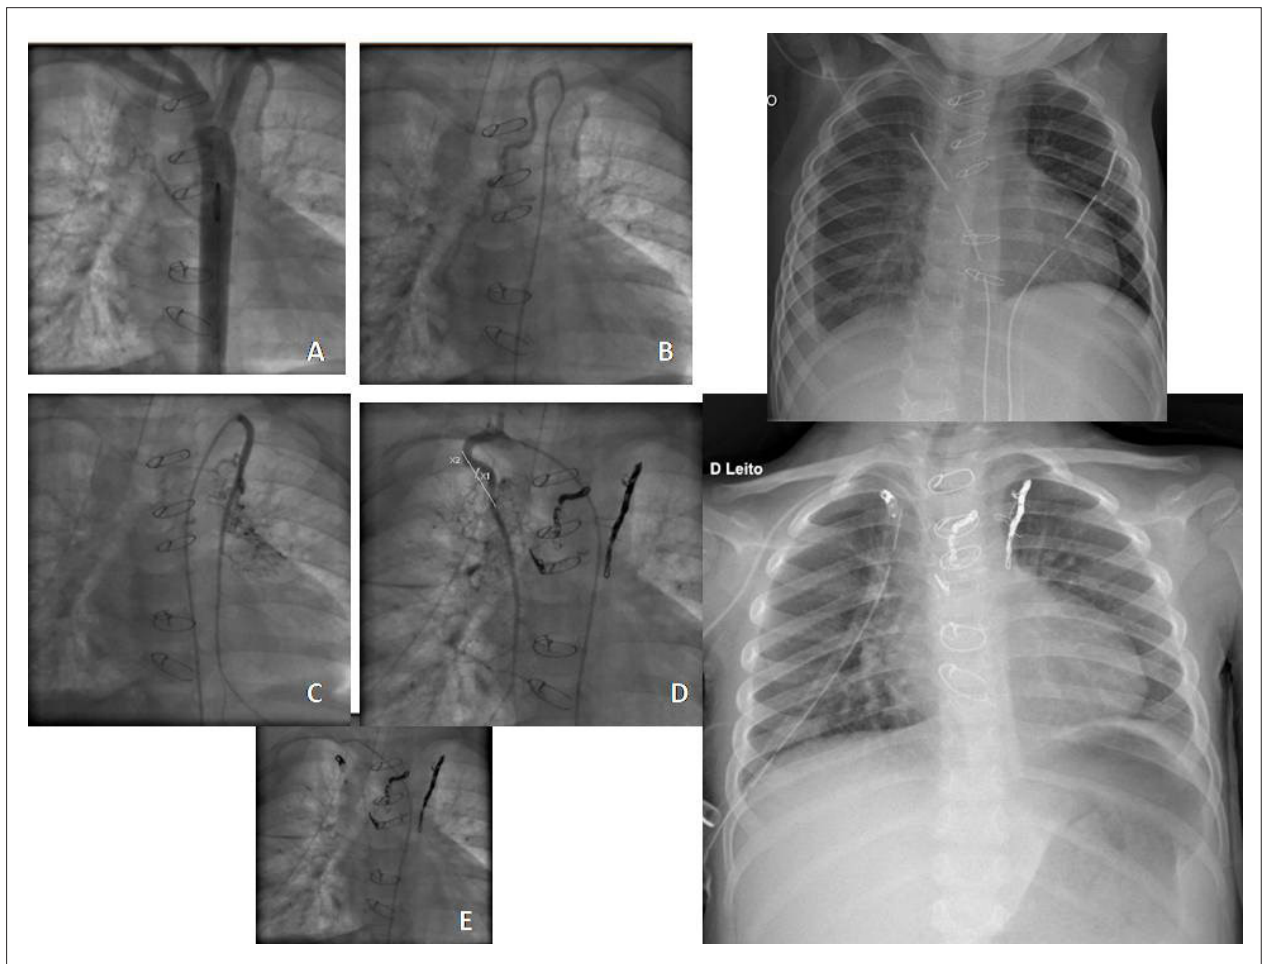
Placement of arterial coils and plug for the closure of systemic-pulmonary vessels on the 38th postoperative day of the cavopulmonary surgery. In A, the fistula from the descending aorta to the right lung, in B and D from the right internal thoracic artery to the right lung, and in C, from the left thoracic artery to the left lung and in E, the arterial coils and plug after the entire procedure. The previous chest x-rays (with pleural effusion) and subsequent one (without pleural effusion), after the procedures.
